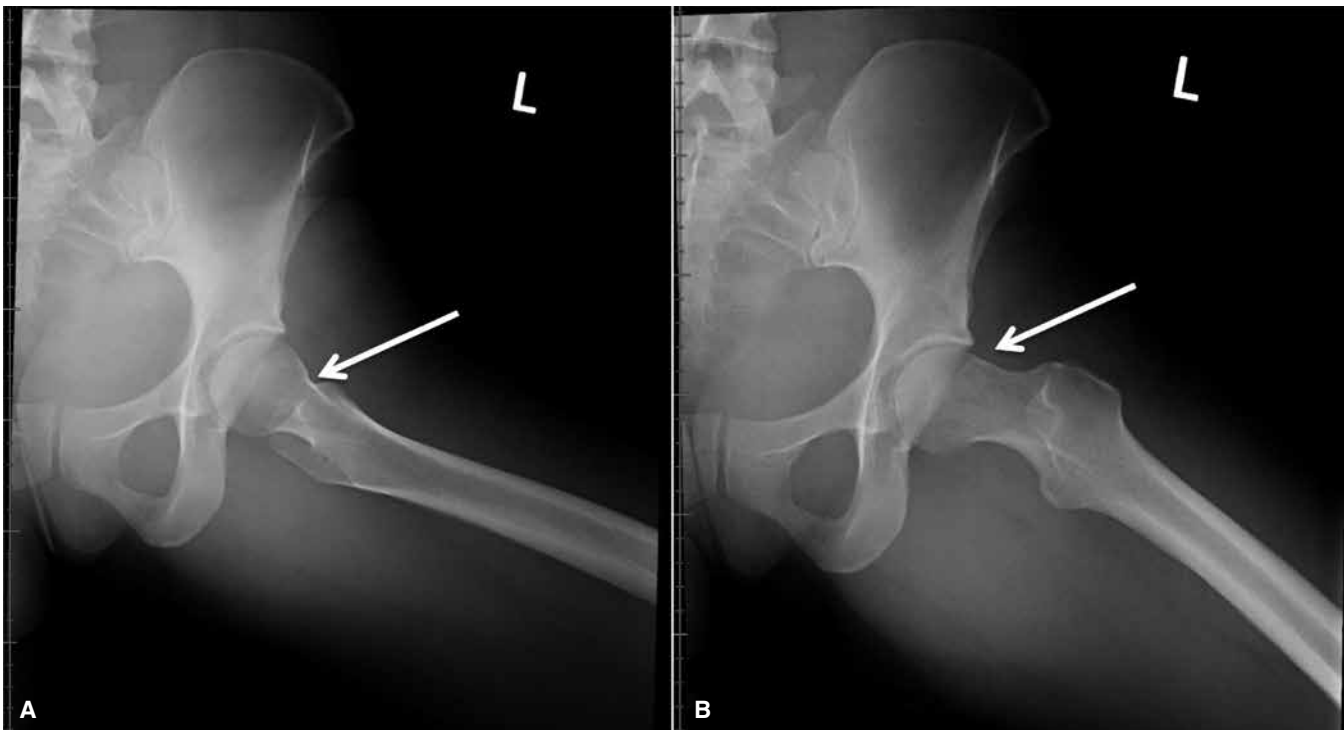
(A) Left Frog-leg lateral view radiograph of a 28-year-old female patient. (B) Left Dunn elongated lateral view radiograph of the same 28-year-old patient. These views allow for the anteroinferior and anterosuperior aspects of the femoral neck and head to be evaluated.
